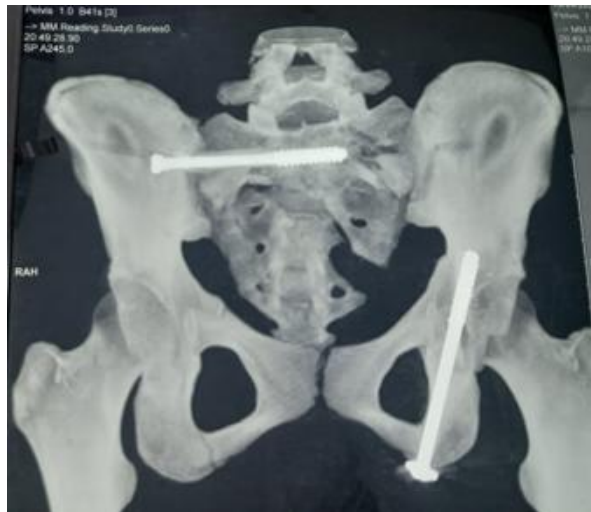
Postoperative CT scan of the pelvis
